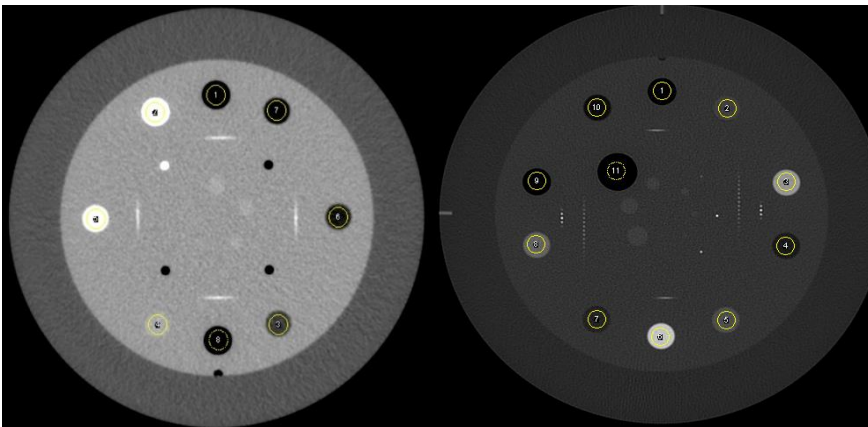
CT CATPHAN image
